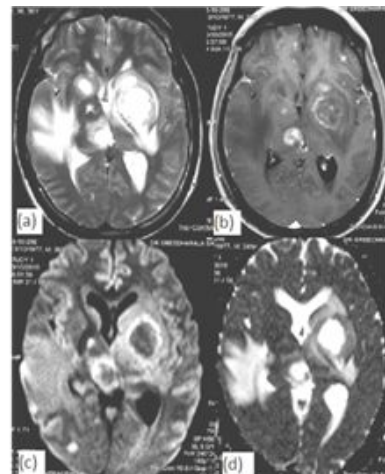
A 38 year old female with toxoplasmosis in RVD positive patient. Fig.(a) hyperintense lesions with perilesional edema in left basal ganglia and right thalamus on T2W image; Fig (b) post contrast T1W image shows peripherally enhancing abscess in left basal ganglia and nodular enhancing lesion in right thalamus, Fig. (c&d) shows non restriction of the abscess with core ADC value of $135 \times 10^{-5} \text{ mm}^2/\text{s}$ on DWI.
